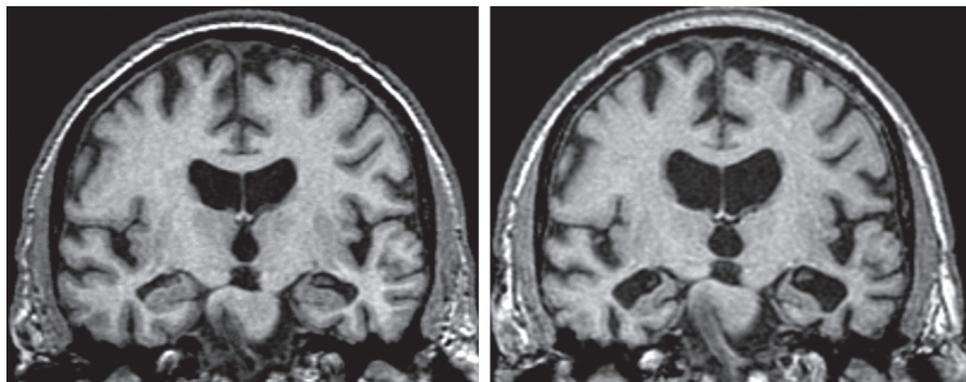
Serial coronal images from MRI of a patient with Alzheimer's disease. The scan on the left was performed when the patient was clinically normal. The scan on the right was performed 11 years later when the patient was demented. Hippocampal atrophy has increased dramatically from the first to the subsequent scan. (Courtesy of Maria Shiung and Clifford Jack.)
